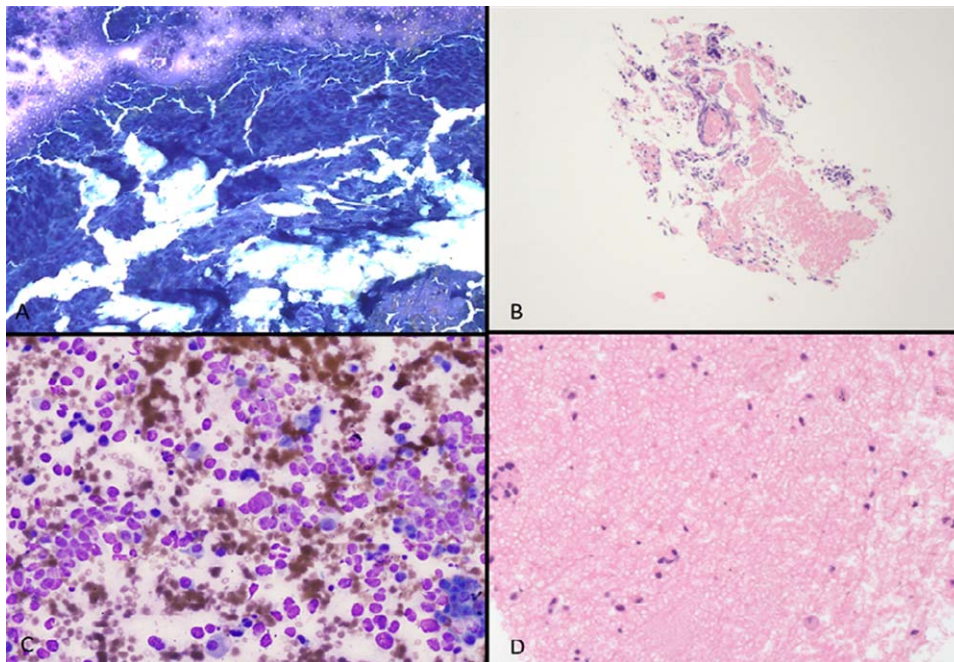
(A,C) Air-dried Diff-Quik smears and (B,D) corresponding cell blocks from endobronchial ultrasound-guided transbronchial needle aspirates from the mediastinal lymph node (low magnification for panels A and B and high magnification for panels C and D).
